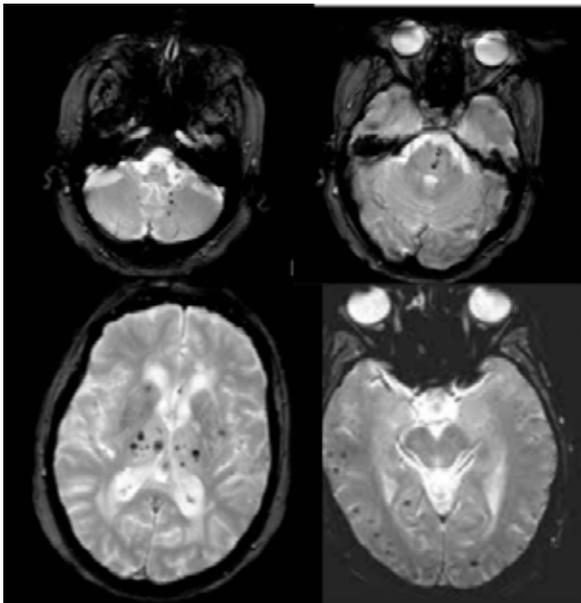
Cerebral microbleeds in infratentorial, deep and lobar regions on T2\* GRE MRI sequences of the cerebral microbleeds study sample
